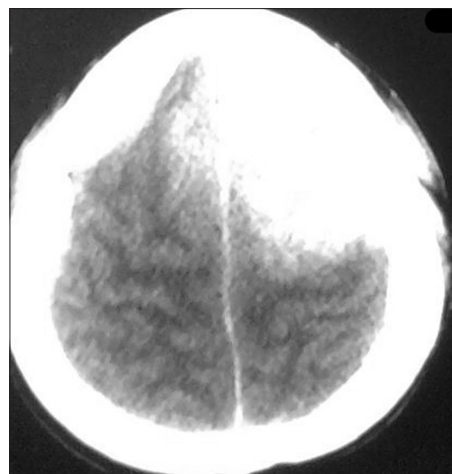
Brain CT showing biconvex high density in vertex
